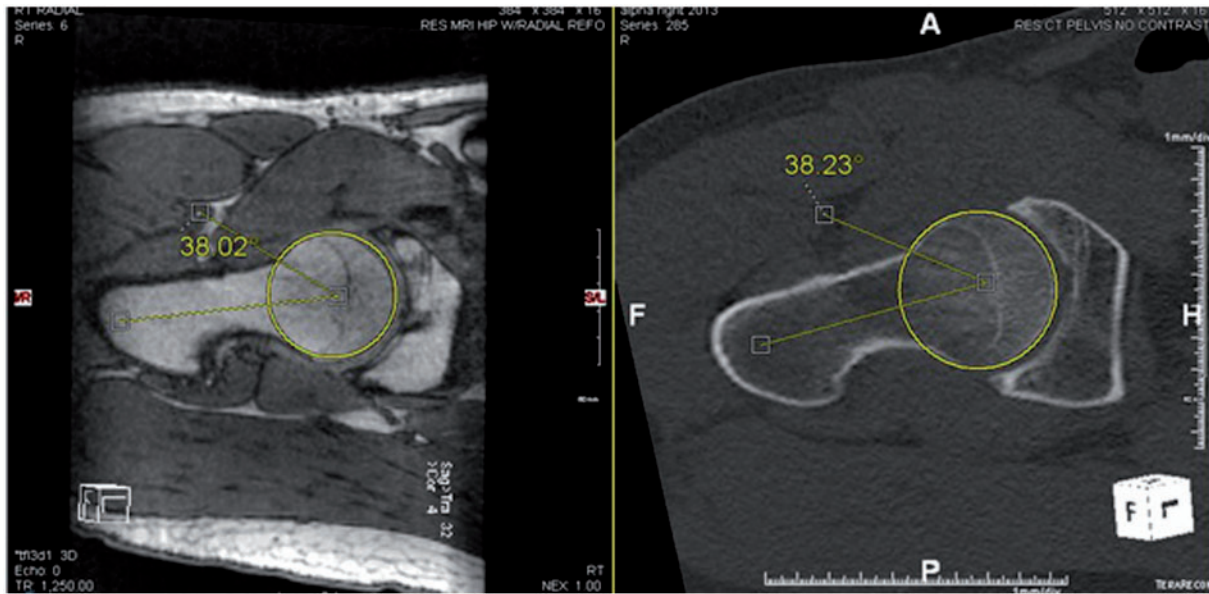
MRI and CT of the same hip at different time points demonstrating measurement of the alpha angle at the 3 o'clock position.
